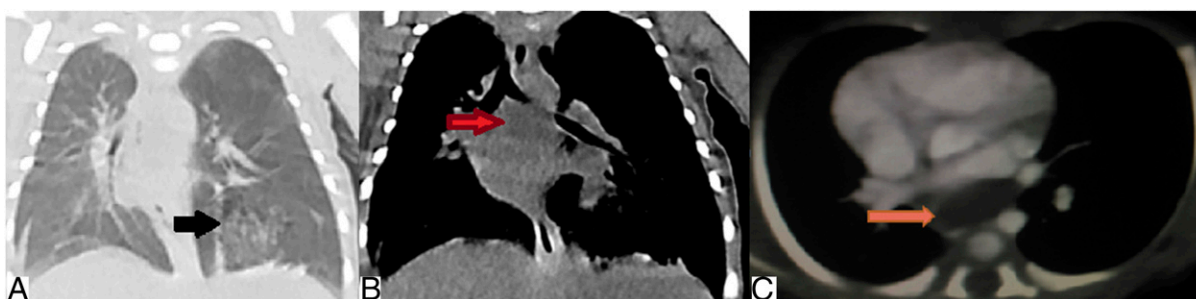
A–C. Computed tomography scan showing the presence of congenital pulmonary airway malformation (black arrow) and posterior mediastinal cyst (red arrow) with mediastinal shift.
